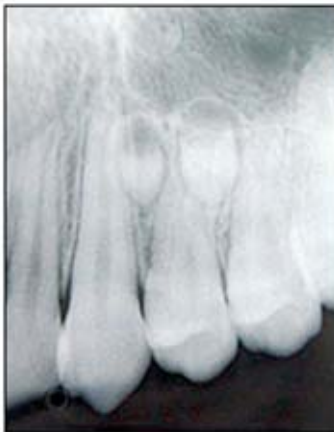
Periapical radiograph showing the presence of supernumerary teeth in the left maxilla.
